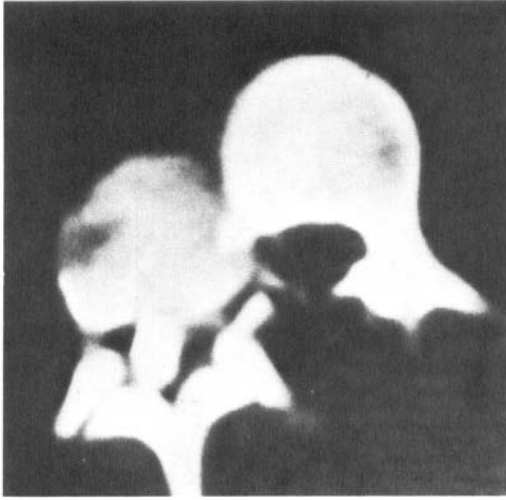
CT shows dislocation and fractured right pedicle and left pars interarticularis of L3.
